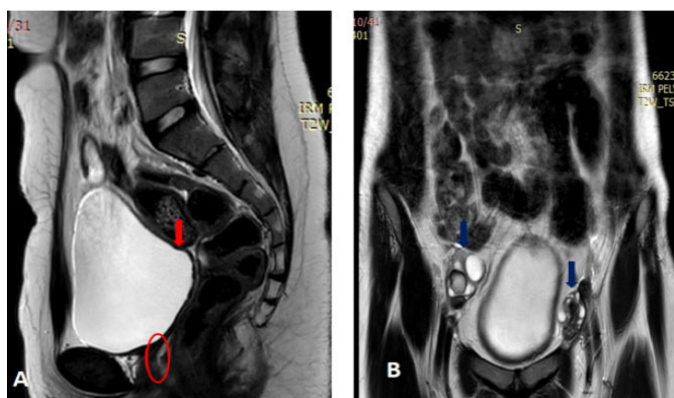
Pelvic MRI T2-weighted sagittal plane (A) showing uterine agenesis (red arrow), inferior vaginal remnant (red circle) and in coronal plane (B) normal ovaries (blue arrows).
